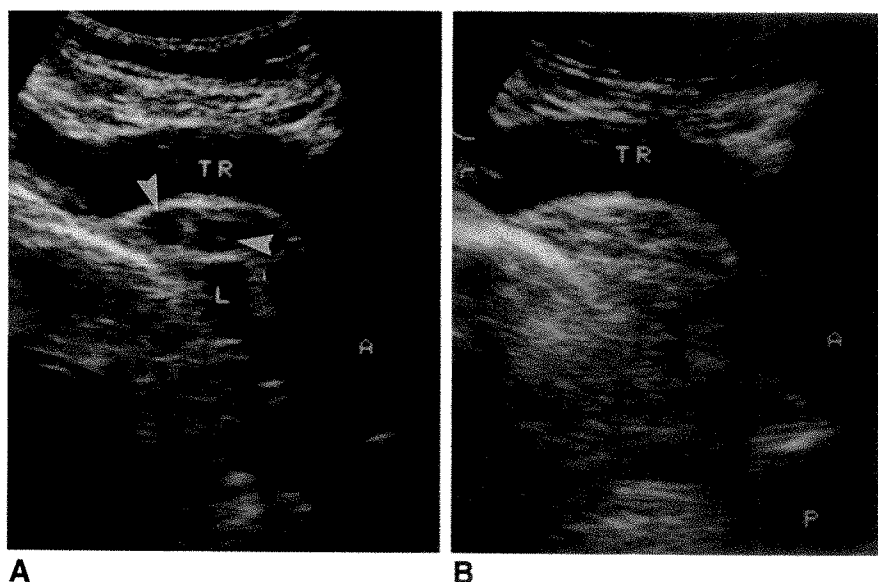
Follow-up sonograms in a 36-year-old man with extensive infiltration of thymus by Hodgkin lymphoma.
